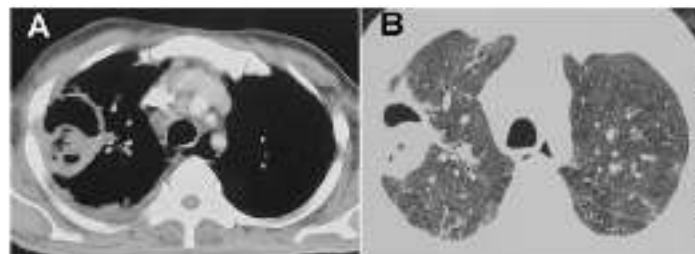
Computed tomography showing thick-walled cavity in the right upper lobe in the corresponding mediastinal A and lung window B windows
